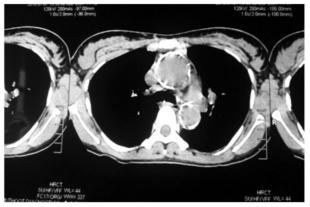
CT thorax Thickened aortic wall with calcification
